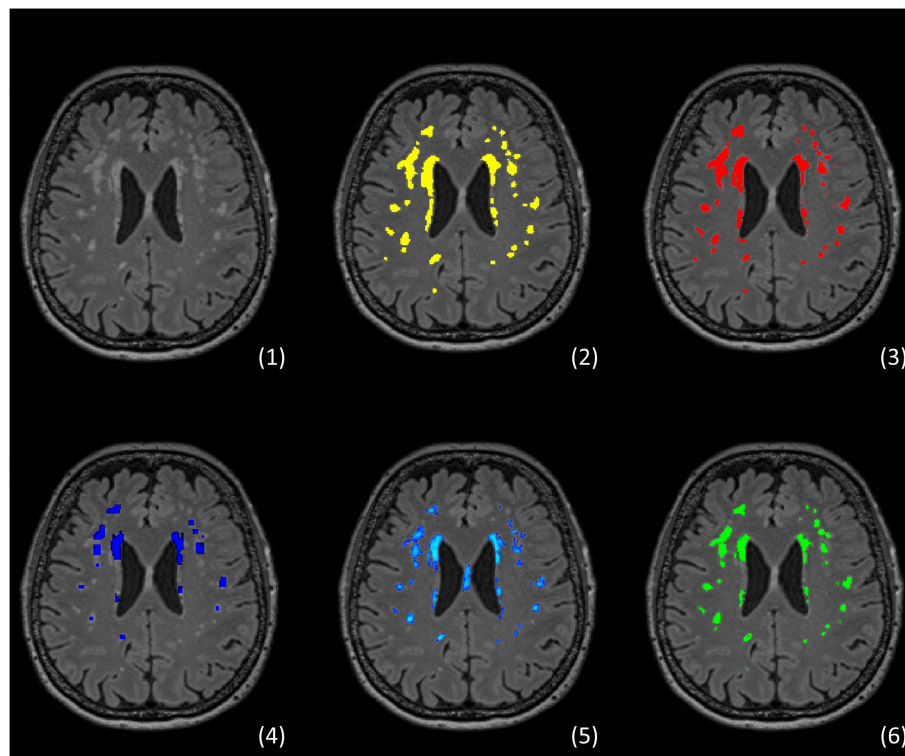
Example of segmentation of white matter hyperintensities (WMH) using different approaches. The figure shows an example from an own unpublished dataset: (1) FLAIR showing typical distribution of WMH, (2) manual segmentation rater 1 (MP), (3) manual segmentation rater 2 (CM), (4) automated segmentation via Lesion growth algorithm (LGA) of LST toolbox version 2.0.15 (22), (5) automated segmentation via Lesion prediction algorithm (LPA) also of LST toolbox, (6) automated segmentation via the Brain Intensity AbNormality Classification Algorithm (BIANCA) implemented in FSL (23).
